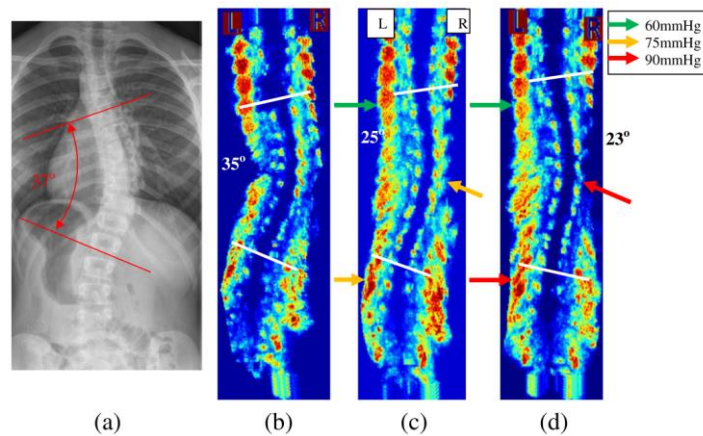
a) The standing pre-brace radiographs with Cobb angle 37°, b) The baseline US scan (Cobb angle 35°), c) The first trial US scan (Cobb angle 25°), and d) The 2nd trial US scan (Cobb angle 23°) (Edmond *et al.*, 2017)
